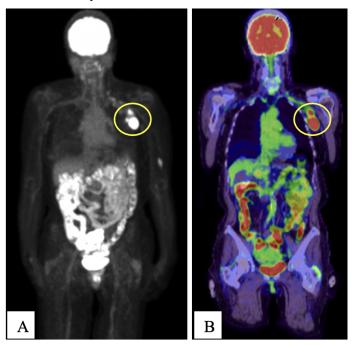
PET CT full body showing hypermetabolic left axillary nodules (yellow circle) and lymphoid masses; In 4B, red represents high metabolic activity, green represents moderate metabolic activity and blue represents low metabolic activity. As seen in this image, left axillary mass has high metabolic activity given malignancy.
